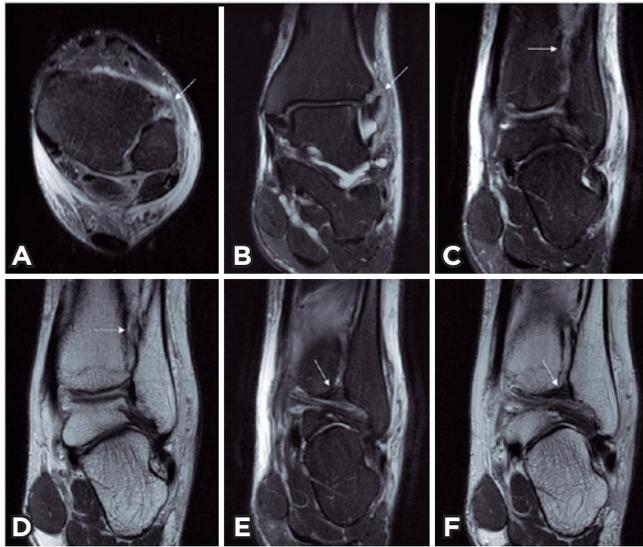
MRI of the left ankle. An axial T2-weighted fat-suppressed image shows complete tear of the anterior inferior tibiofibular ligament (A – white arrow). A coronal T2-weighted fat-suppressed image shows complete tear of the anterior inferior tibiofibular ligament (B – white arrow). A coronal T2-weighted fat-suppressed image shows complete tear of the interosseous ligament (C – white arrow). A coronal DP-weighted image shows complete tear of the interosseous ligament (D – white arrow). A coronal T2-weighted fat-suppressed image shows an intact posterior inferior tibiofibular ligament (E – white arrow). A coronal DP-weighted image shows an intact posterior inferior tibiofibular ligament (F – white arrow).
